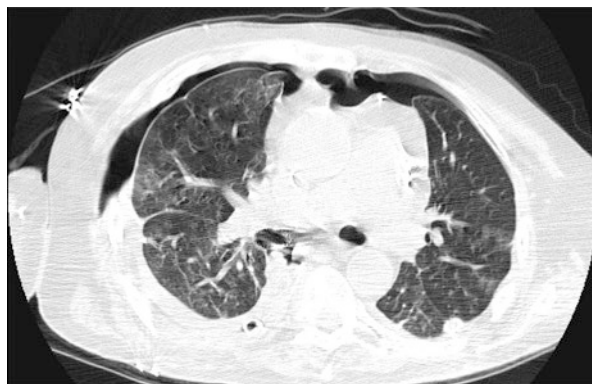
(a–d) A 40-year-old male status post lung transplant with serial axial CT images (a–d) demonstrating extensive bilateral ground-glass opacities and trace bilateral pleural effusion in the setting of acute rejection
